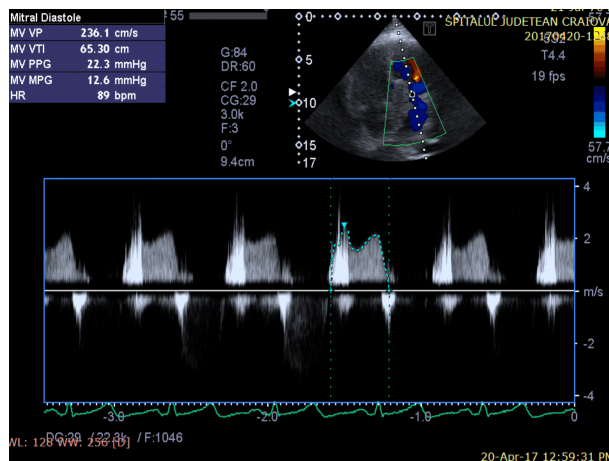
Transthoracic echocardiography (TTE) which highlights high diastolic gradients across mitral valve (severe functional mitral stenosis) on continuous-wave Doppler (CWD).
